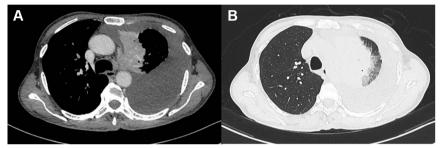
(A) Computed tomography scan of the thorax (mediastinal window) above the level of carina showing a mass lesion in the left parahilar region along with significant left pleural effusion. (B) CT scan of the thorax (parenchymal window) showing grossly normal right lung parenchyma and left lung findings as described above.
